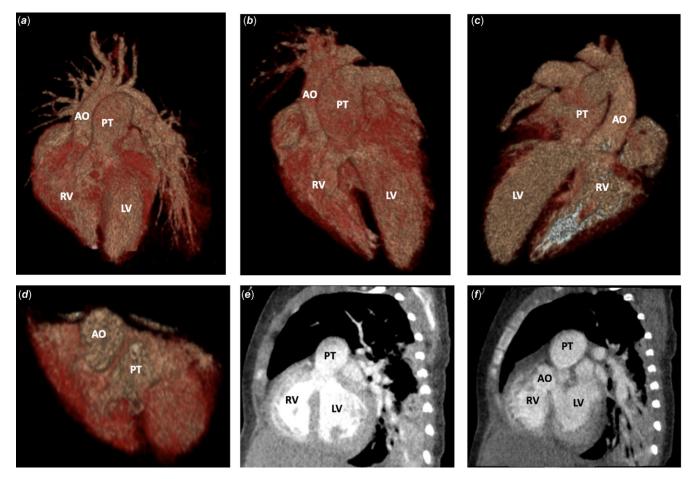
Computerized tomography (CT) angiography images. (*a* and *b*) Volume Rendering Technique (VRT) images showing the anterior plane of the heart. (*c*) VRT image showing the posterior plane of the heart. (*d*) VRT image showing the axial plane of the heart. (*e*) Sagittal plane showing the pulmonary artery overrides to both ventricles. (*f*) Sagittal plane showing the aorta overrides to both ventricles. Ao=aorta; PA=pulmonary artery; RV=right ventricle; LV=left ventricle.
